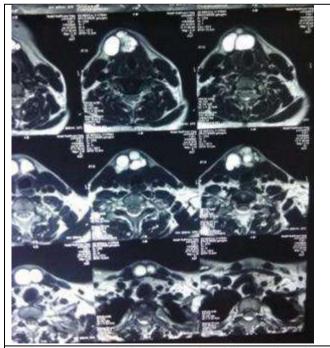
MRI Neck Showing Anterior Midline Cystic Lesion with Features Suggestive of Thyroglossal Cyst
